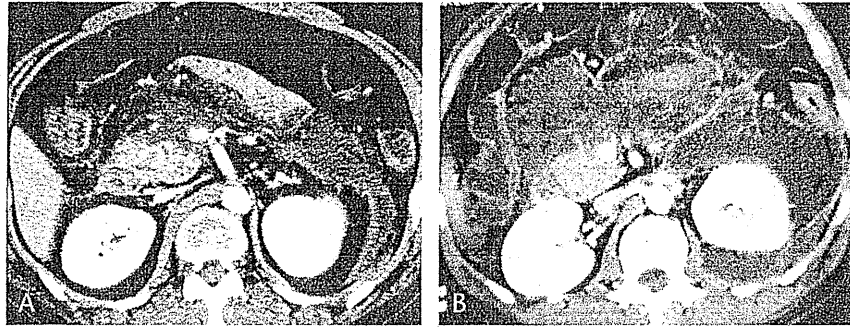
Computed tomographic images of a patient whose RRG progressed from grade B to C after 2 weeks. A, Computed tomographic image at admission (grade B, renal rim sign is positive). B, Computed tomographic image 2 weeks after admission (grade C, loss of renal rim sign is positive).
